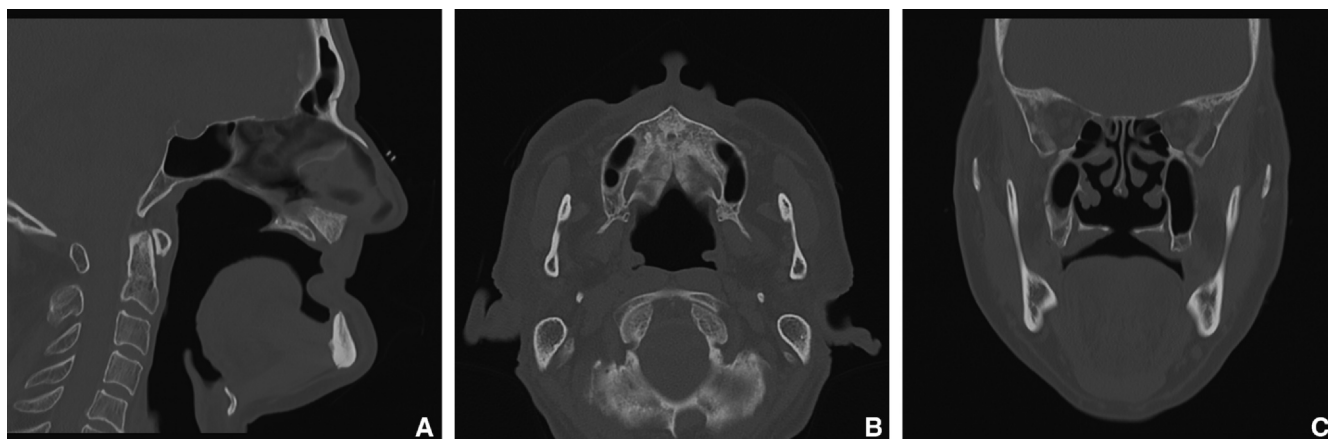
Computed tomography images. Fusion of posterior hard palate, soft-palatal aponeurosis and missing uvular muscles. A, Sagittal view. B, Horizontal view. C, Frontal view.
